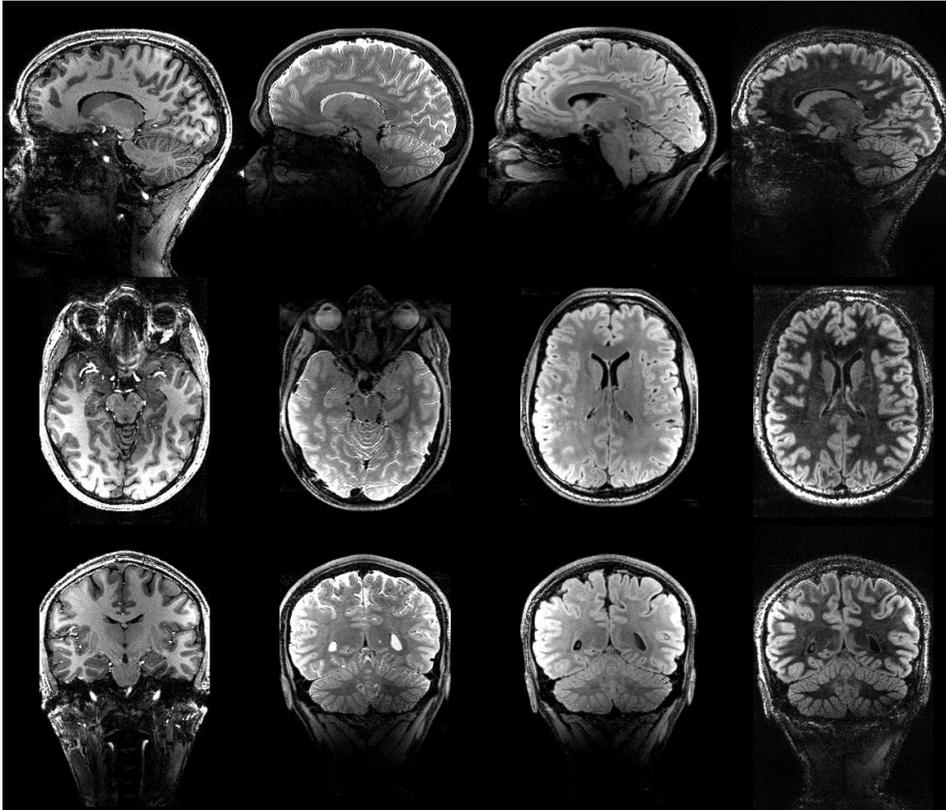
From left to right: MPRAGE, TSE, Magnetization-Prepared FLAIR, DIR images at 7T on one volunteer using the Circularly-Polarized standard mode of excitation (CP) versus calibration-free universal pulses (UP). The images obtained with Universal Pulses are virtually RF field inhomogeneity artefact free.
